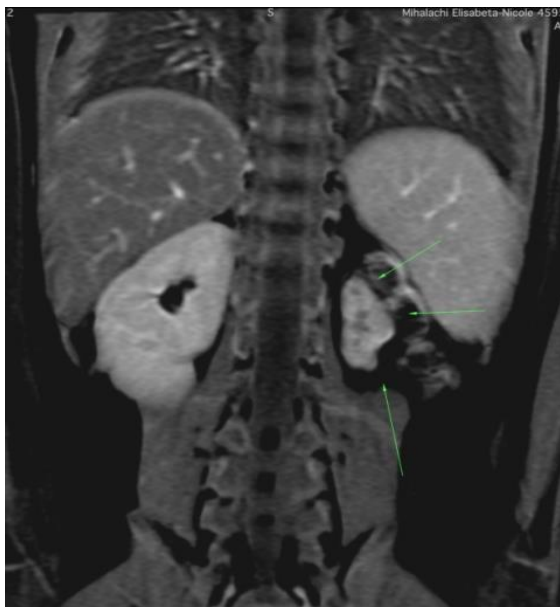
Patient E., MRI performed at 6 months postoperatively. Left kidney atrophy found (explanations in text)
